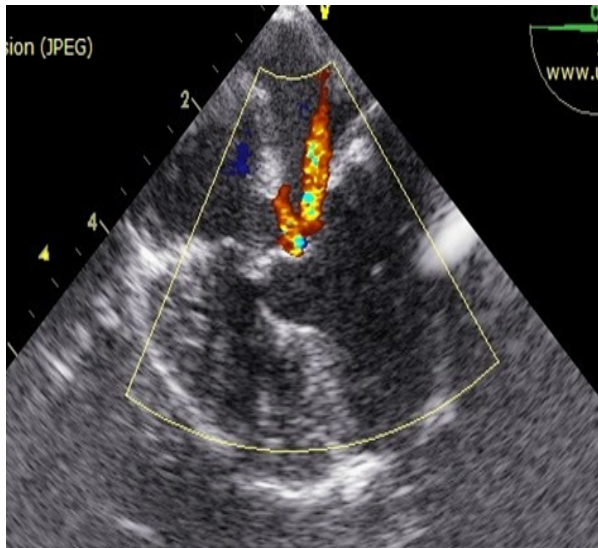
Post-correction transesophageal echocardiogram of twin 1 showing good surgical result, mild regurgitation of the left AV valve.
